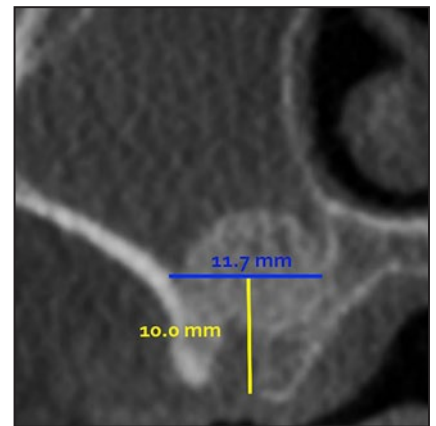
(above) In the transcresal approach, sinus floor opening may be performed using osteotomes, specially designed burs, or ultrasonic devices, respecting the integrity of the sinus membrane.
